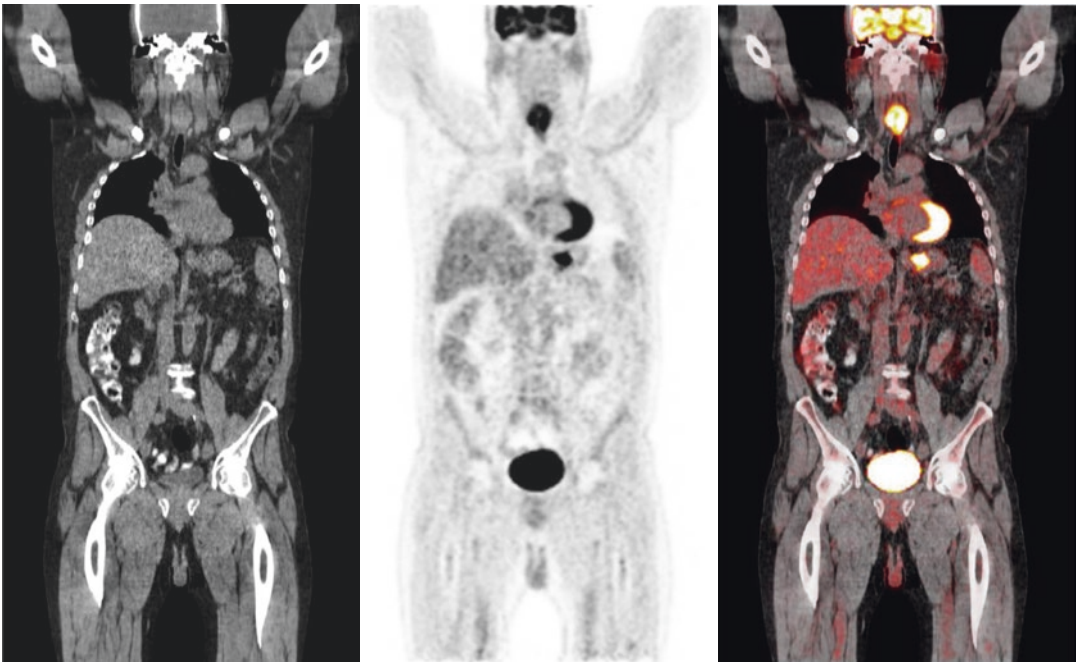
Clinical ^{18}F FDG scan images from a whole-body PET/CT scanner. Shown are CT (*left*), PET (*middle*), and fused PET/CT (*right*) images
